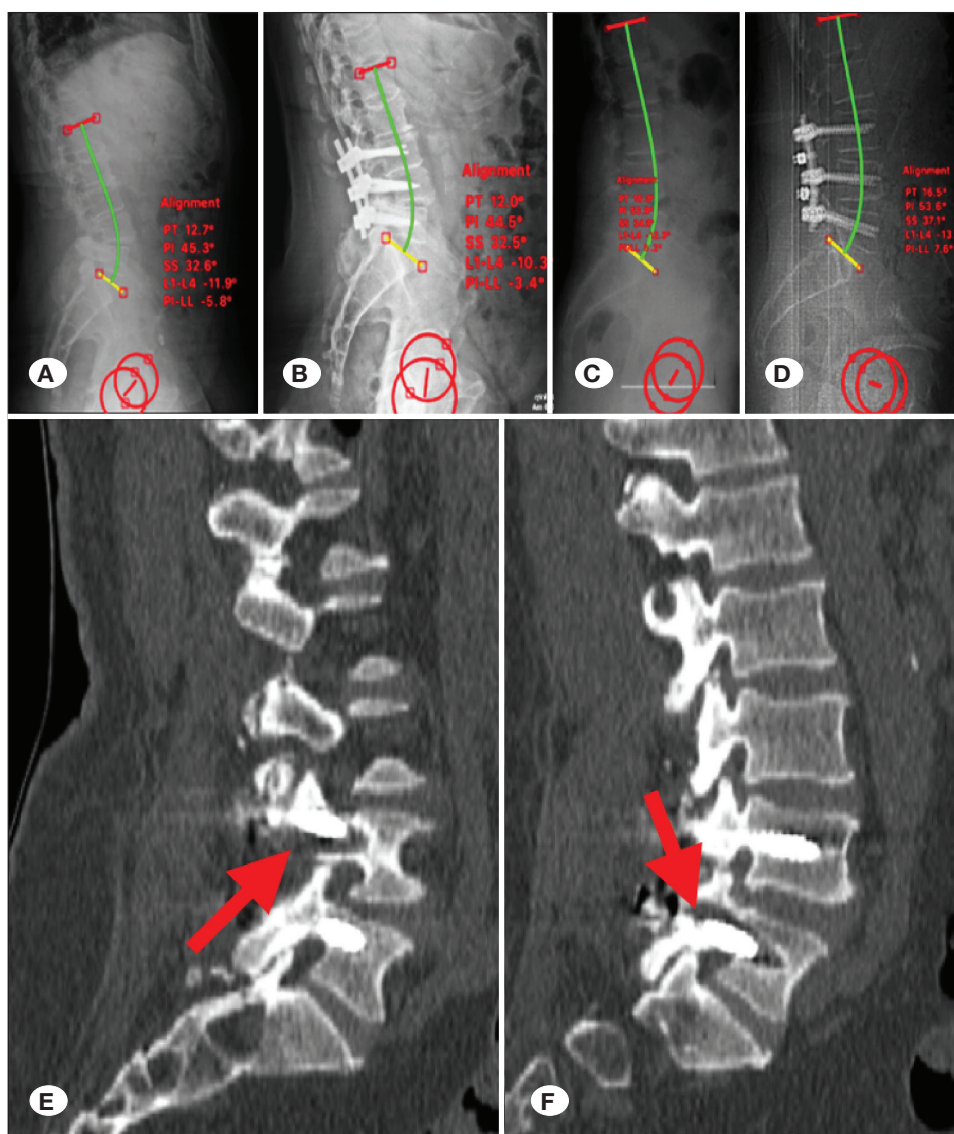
A, C) depict preoperative images showing the measurement of pelvic parameters in patient case examples, B, D) show the postoperative measurements of the same pelvic parameters in these cases, E, F) are sagittal CT images from the cases, highlighting screw loosening, indicated by the red arrows.
